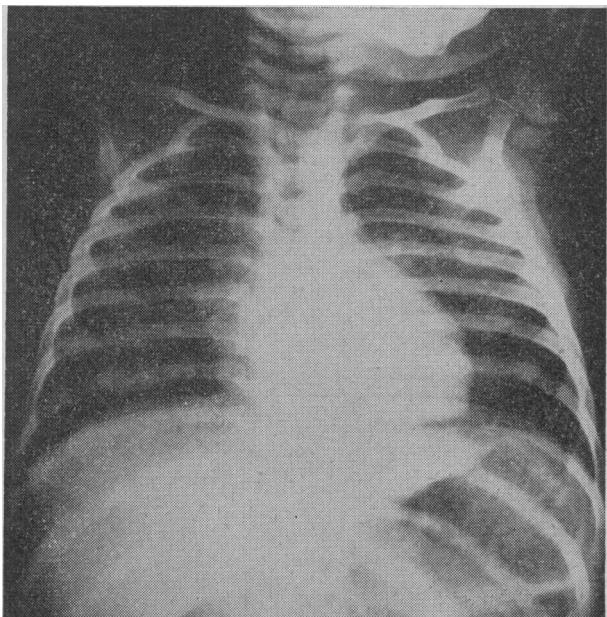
Radiograph taken on November 8 showing diffuse miliary shadowing throughout both lungs.
